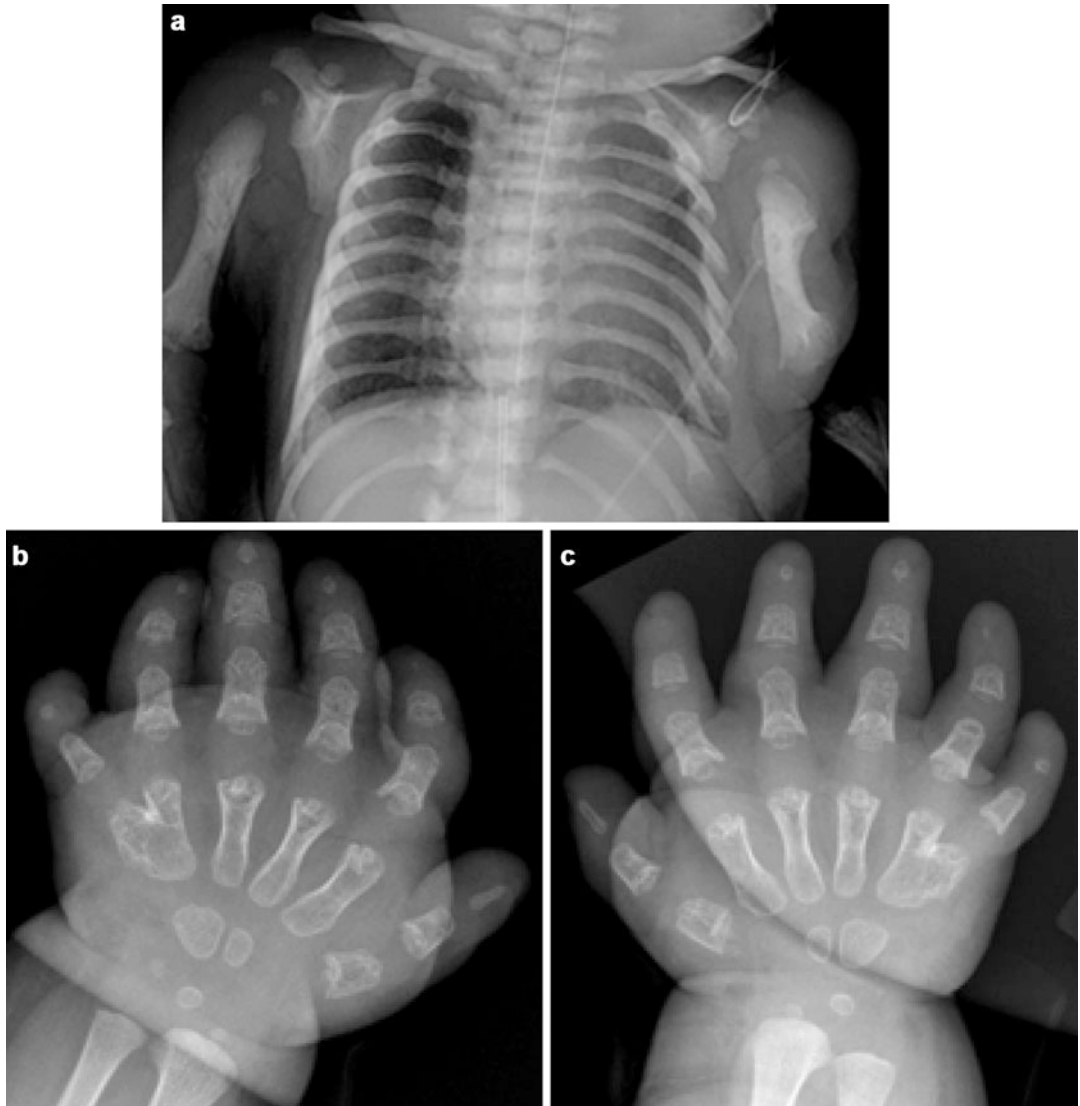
(a–c) Chest radiography at 3 weeks age (a) showed a small rib cage with short ribs and small scapulae bilaterally. The humeri were hypoplastic and deformed. Radiography of hands showed six rays bilaterally. The phalanges were short and thickened with irregular metaphyses. Distal
